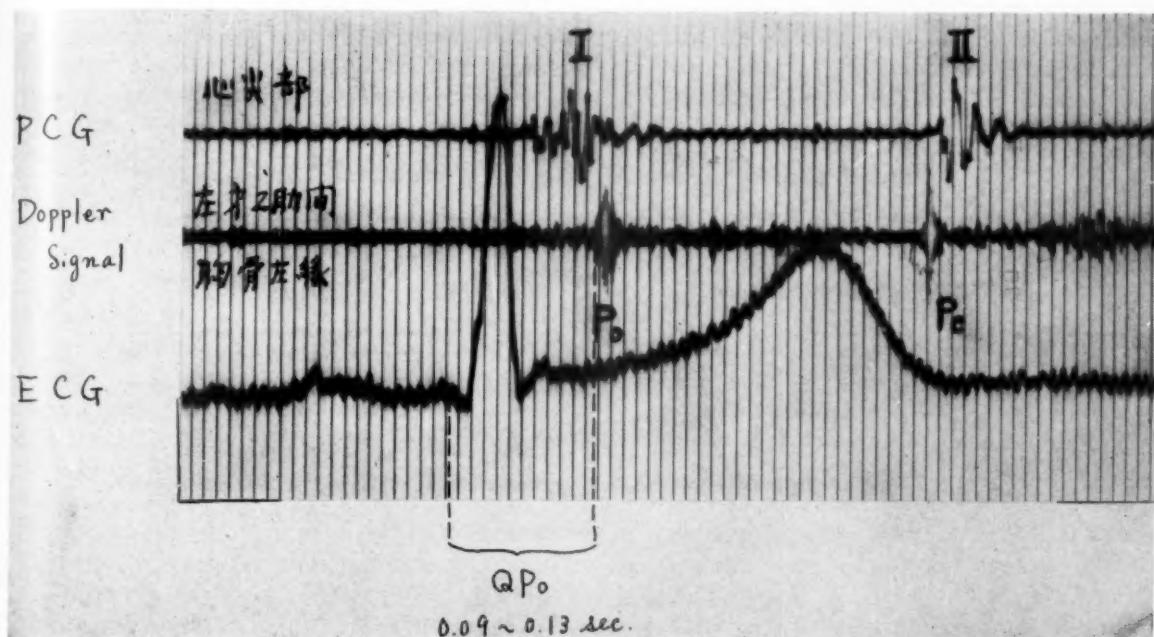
Ultrasonic Doppler signal of high frequency related to the pulmonic valve. Po : Opening. Pc : Closing. The end of Pc coincides with the beginning of the second heart sound. (S. T., a 30-year-old healthy man.)
